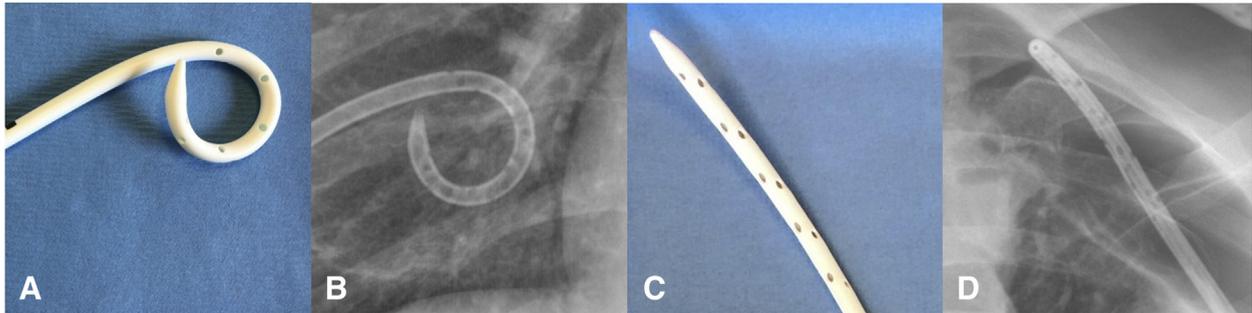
Physical and radiographic appearances of catheter, correct and incorrect. (A) Photograph, *without* the stiffening obturator in place. The catheter tip assumes its namesake “pigtail” shape. (B) Radiographic appearance, *without* the stiffening obturator device in place. The “pigtail” shape is visible. The catheter appears hollow [compare with (D)]. (C) Appearance with stylet in place (straight). The pigtail shape is absent. (D) Radiographic appearance with the stiffening obturator in place. The catheter appears unexpectedly straight. A “tube within a tube” appearance is present, because the obturator fills the normal lumen of the 14.0-Fr catheter [compare with (B)].
